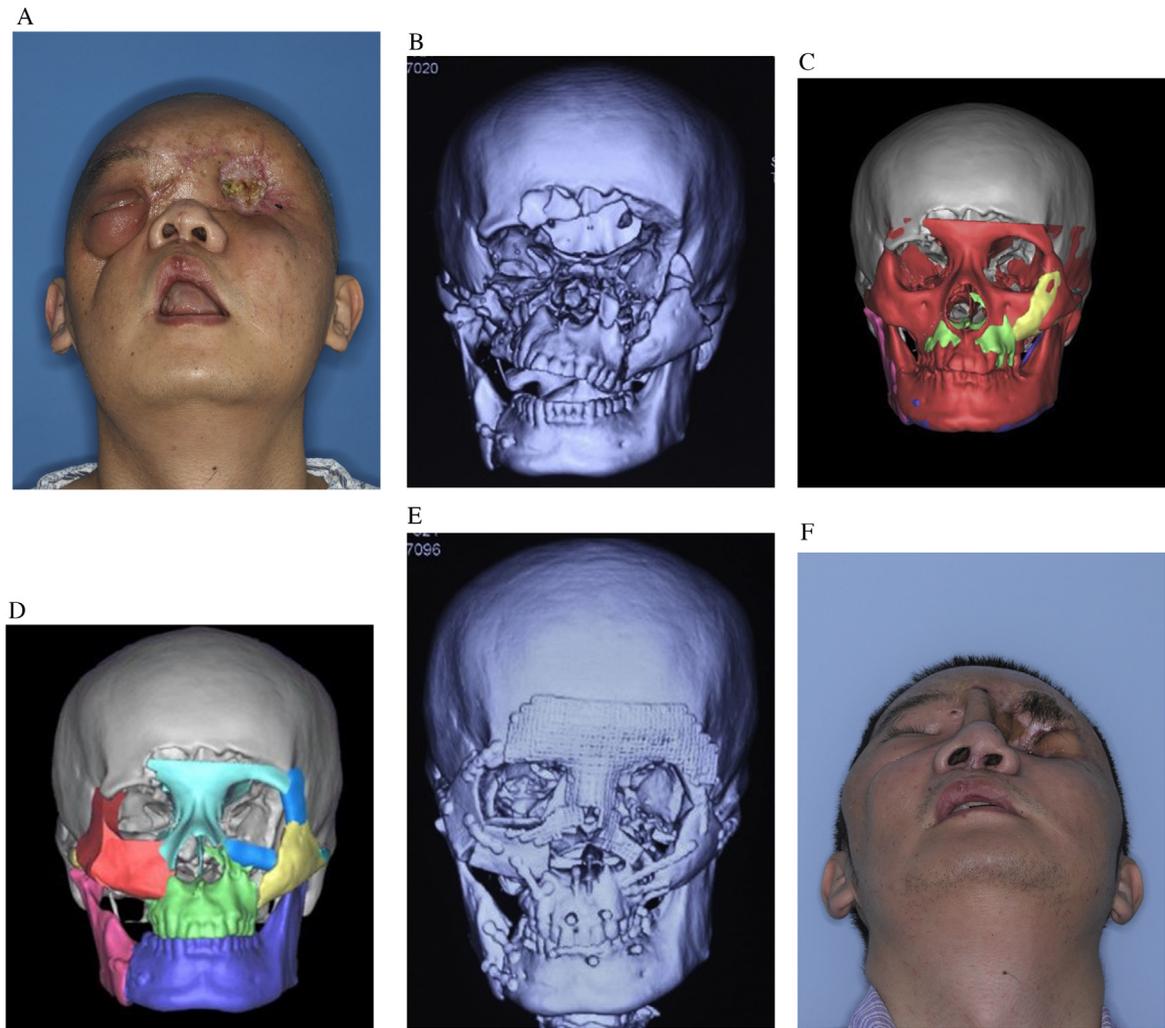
Reconstruction according to reference data obtained from the database for a bilateral defect and fracture across the midline. Preoperative (A) photograph and (B) CT scan of the patient, showing a large area of bone defect including the frontal bones, naso-orbital-ethmoid bones, right zygoma, part of the left zygoma, and anterior skull base. (C) Virtual reconstruction according to the reference data obtained from the database. (D) A titanium mesh prosthesis was used to repair the frontal naso-orbital-ethmoid defect; a DCIA flap was used to reconstruct the right zygoma; a non-vascularized bone graft was used to rebuild the left orbit. (E) Postoperative CT scan after reconstruction with the DCIA flap and titanium mesh. (F) Photograph of the patient at 1.5 years postoperative.
